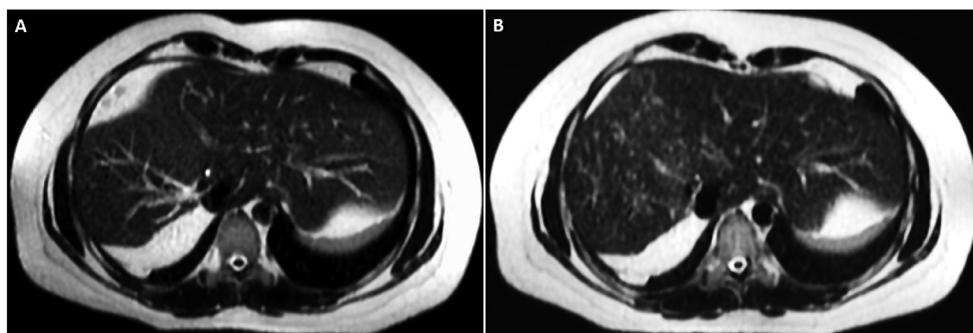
Magnetic resonance imaging, performed in 2015 after surgical resection of hepatic giant hemangioma (A), showing the complete absence of lesions in the residual segments of the right hepatic lobe, subsequently affected by the hemangiomas. The magnetic resonance imaging follow-up, performed in 2017 (B), showing that the onset of lesions which were smaller in number and size than the follow-up in 2018 (cfr. Fig. 1B).
